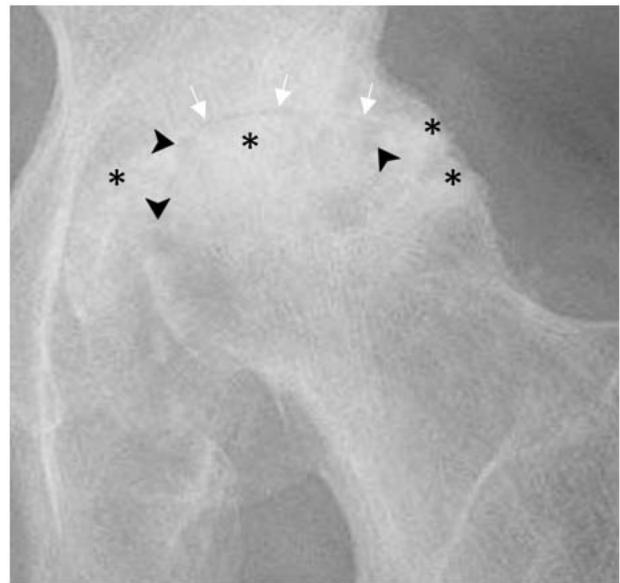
Left hip AP radiograph exhibiting loss of femoral head sphericity and advanced joint disease. Joint space narrowing is indicated with white arrows; geodes are indicated with arrowheads, and sclerosis is marked with asterisks.
